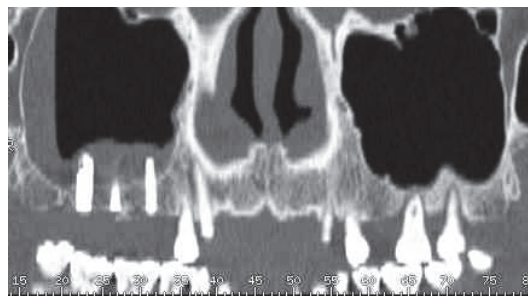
Postoperative CT scan showing membrane elevation in the sinus.
